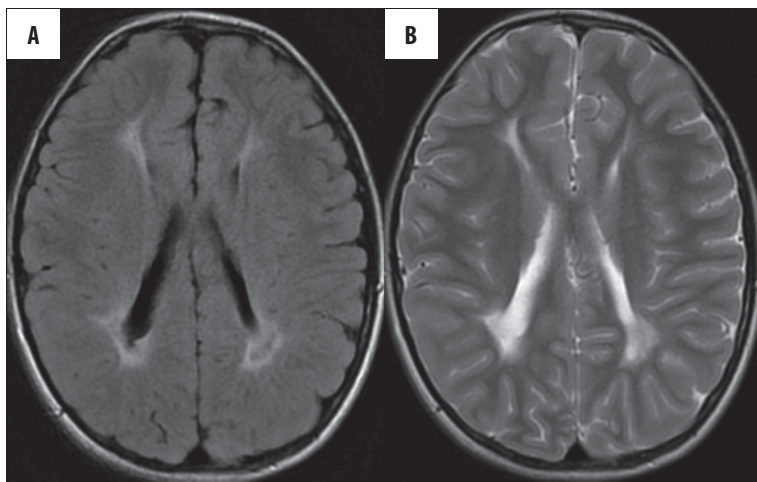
Bilateral, symmetrical paraventricular gliosis, uneven external outlines of the lateral ventricles, thinning of the white matter layer – classic pattern of hypoxic-ischemic lesions in a child born between 32 and 36 week of gestation. (A) FLAIR,ax; (B) FSE/T2,ax.
